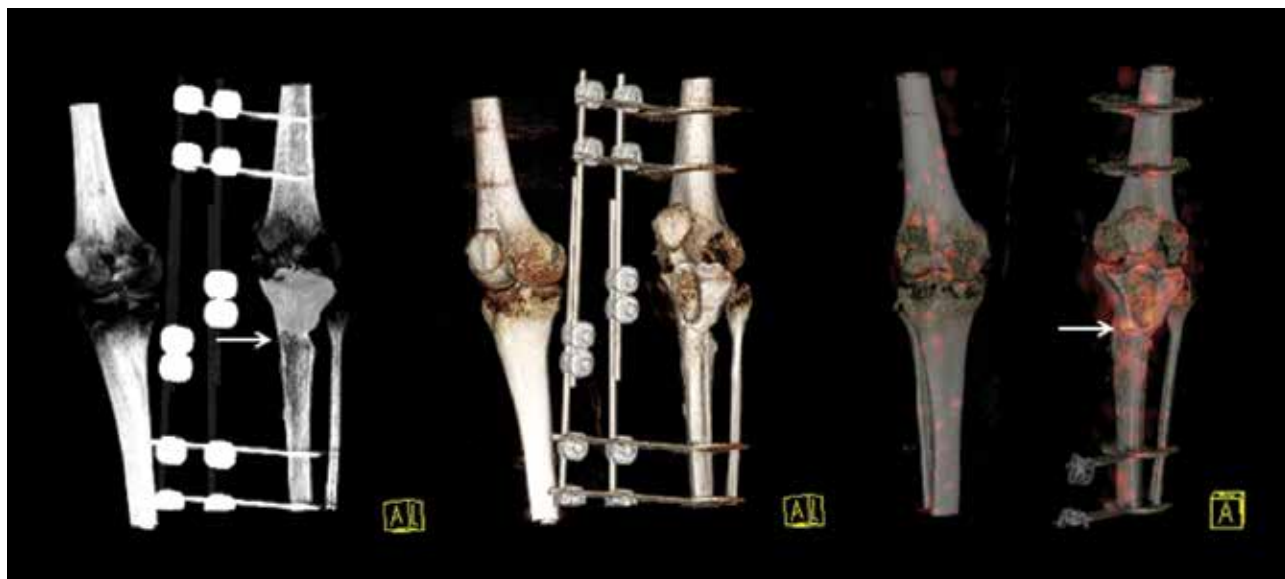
Maximum intensity projection (MIP) and volume rendering of CT of the 5-hour post-injection study show a radiodense cement spacer replacing the proximal tibia articulating with the condylar surface of the left femur. The junction of the cement spacer and the tibial shaft is irregular, suggesting pseudoarthrosis. The external fixation devices are well delineated. The volume rendering of the fused SPECT/CT images show mild increase in uptake of  $^{99m}\text{Tc}$ -labelled antigranulocyte antibodies in the line separating the radiodense cement spacer and the tibial shaft (arrow), reflecting mild accumulation of leucocytes secondary to reactive changes and secondary to pseudoarthrosis at the bone cement junction.
